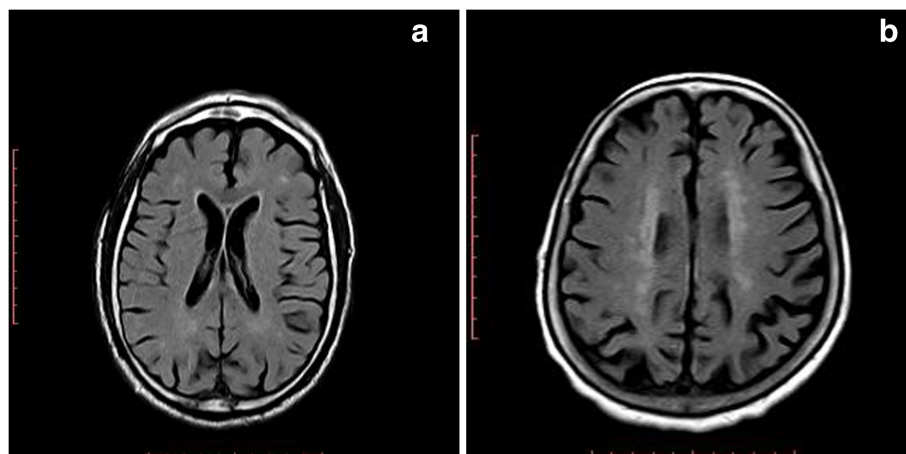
Axial FLAIR in two different patients showing grade 1 (a) and grade 3 (b) white matter hyperintensities according to Fazekas's grading
